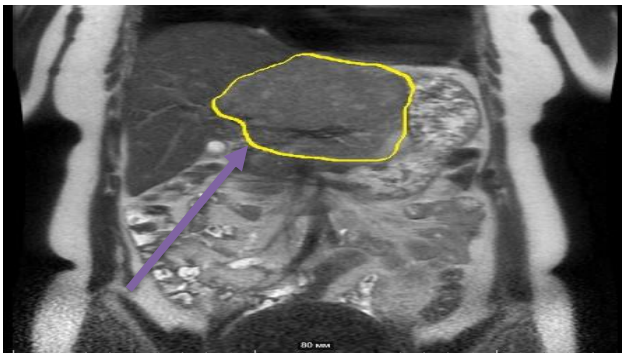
This MRI-scan shows the focal nodular hyperplasia in the left lobe of the liver
